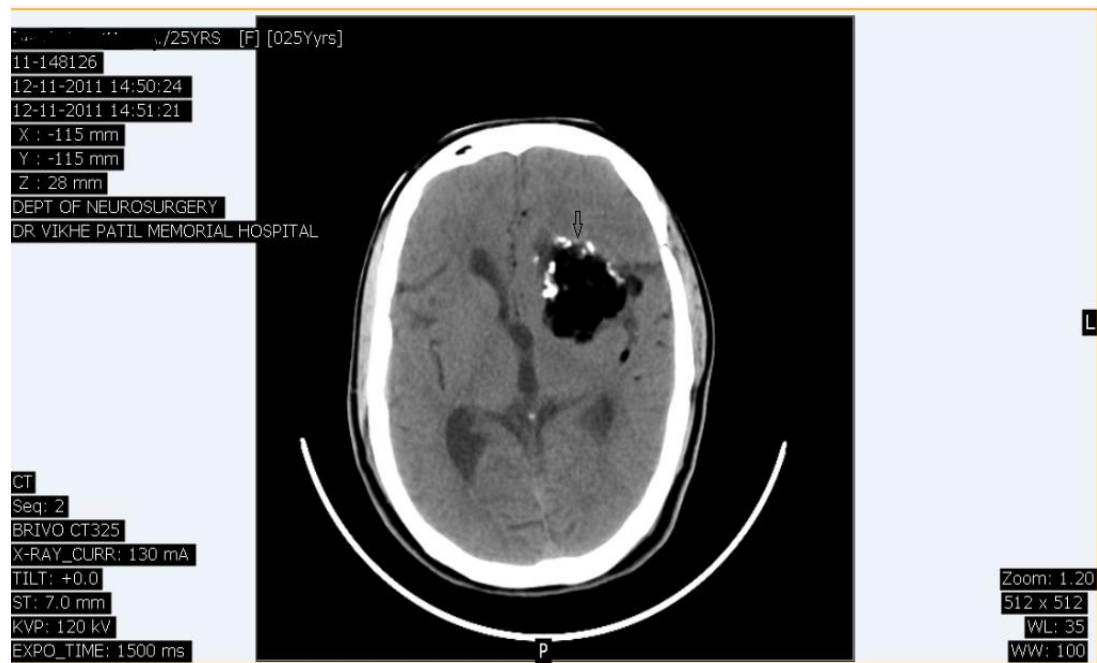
Unenhanced CT scan of brain shows fat density lesion at left temporoparietal region. Partial calcification of the wall of the lesion is seen.
